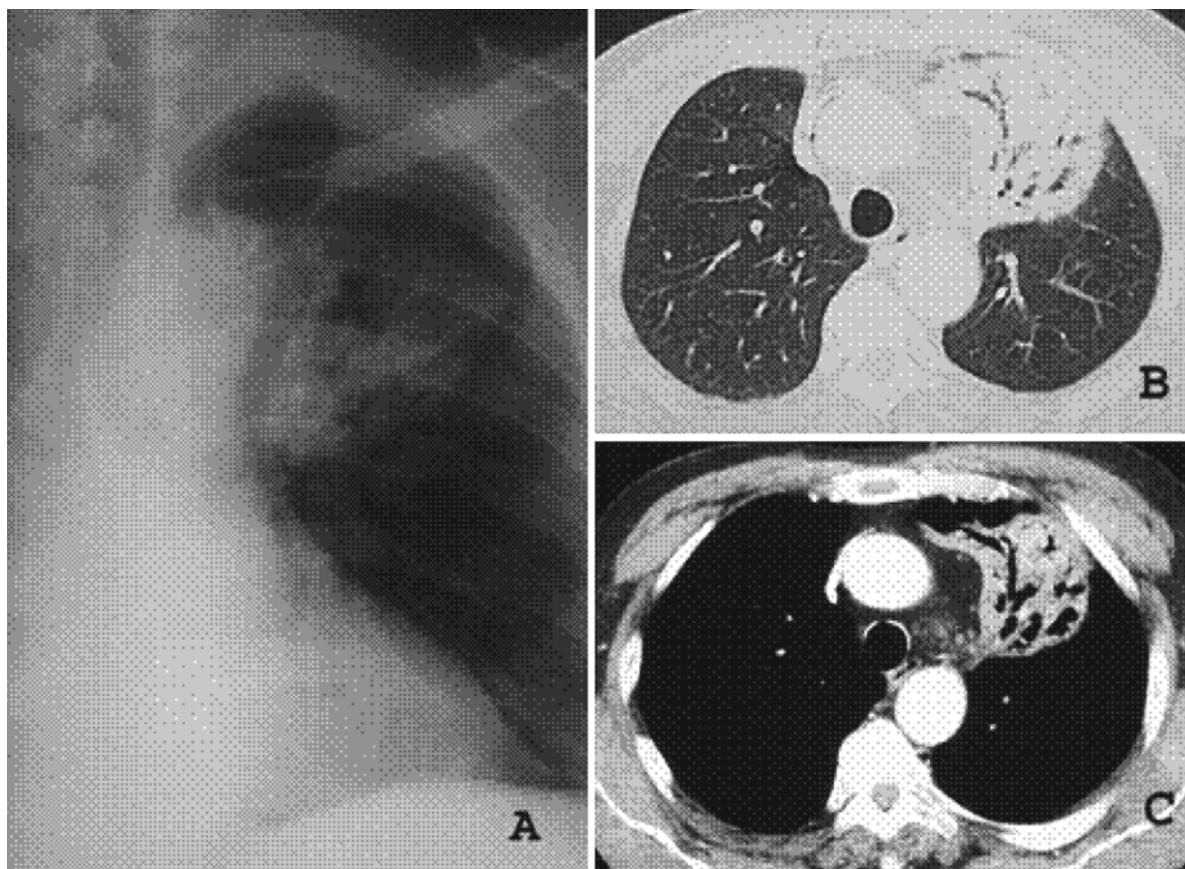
MALT-type pulmonary lymphoma. Chronic alveolar opacity of the left upper lobe with air bronchogram. Chest X-ray (panel A) and CT scan (B and C)
